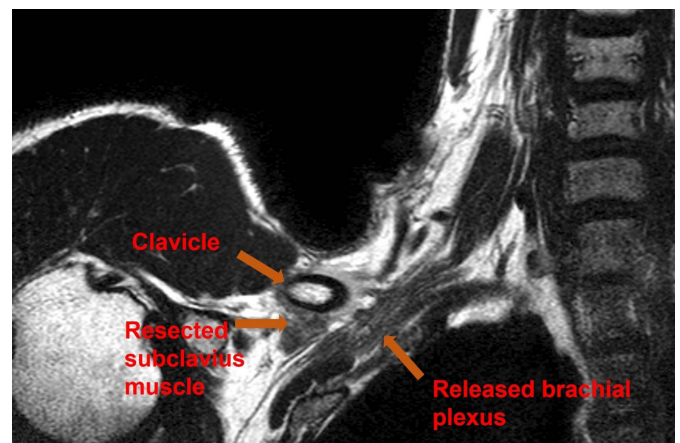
Follow up magnetic resonance imaging in shoulder abduction position after 1 week from operation.
